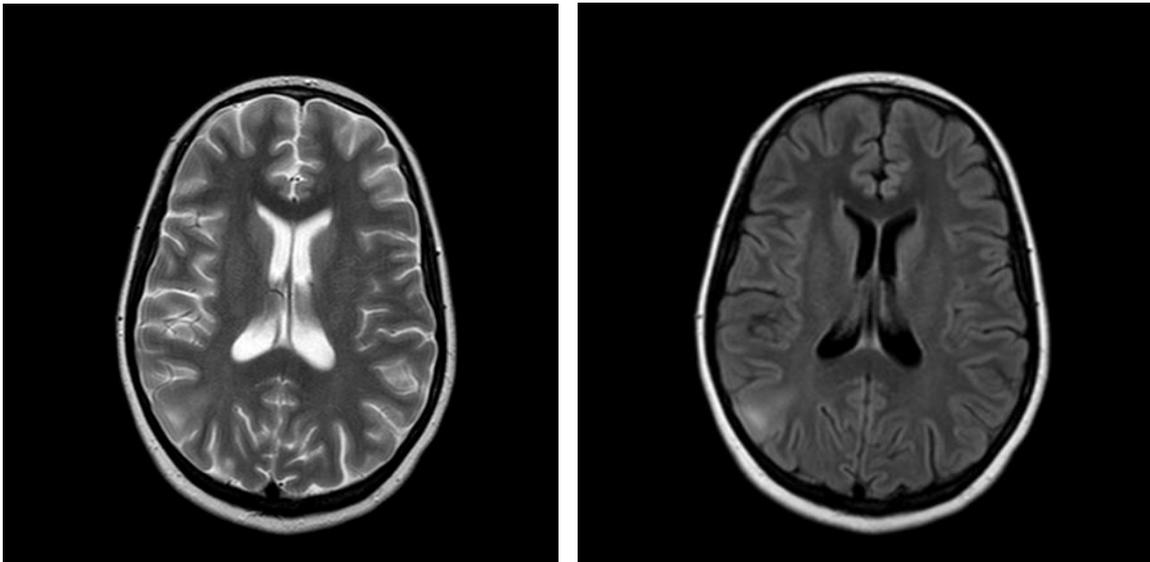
Axial T2W, Axial FLAIR of MRI brain showing Focal Cortical Dysplasia (FCD) in right parietal region. Imaging features:
